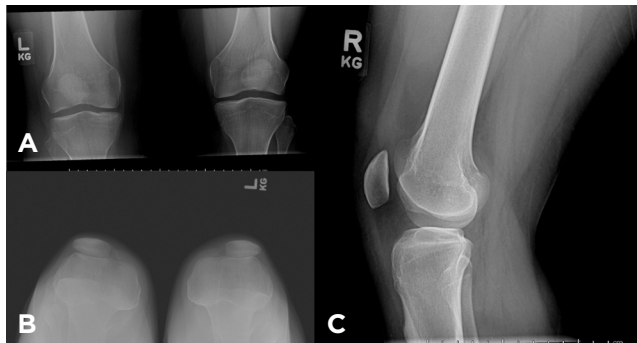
A) Anteroposterior x-ray of bilateral knees; B) merchant x-ray of right knee; C) lateral x-ray of bilateral knees.
